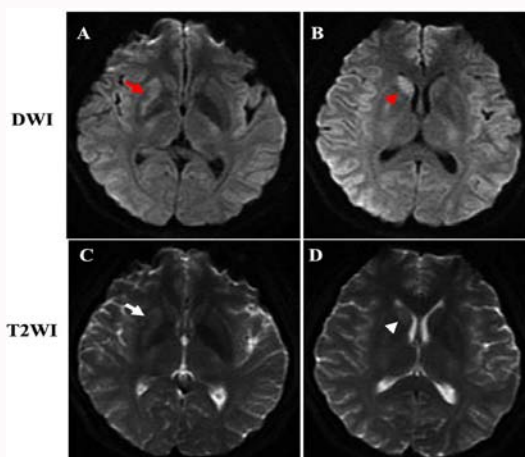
A brain diffusion-weighted image revealed signal hyperintensities in the right putamen (A, red arrow), the right caudate nucleus (B, red arrowhead). Brain MRI revealed abnormal signal hyperintensities on T2-weighted images in right putamen (C, white arrow), the right caudate nucleus (D, white arrowhead).
